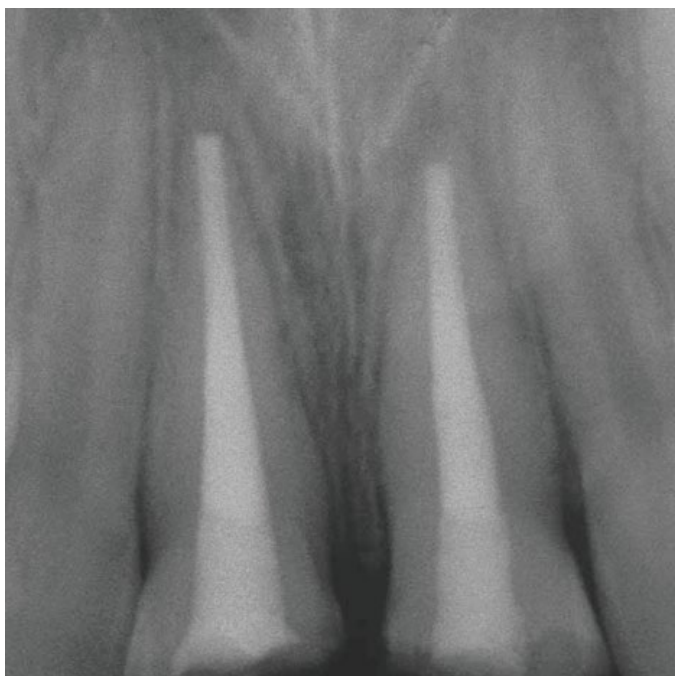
(K) Posttreatment radiograph of the two fractured and restored central incisors.
